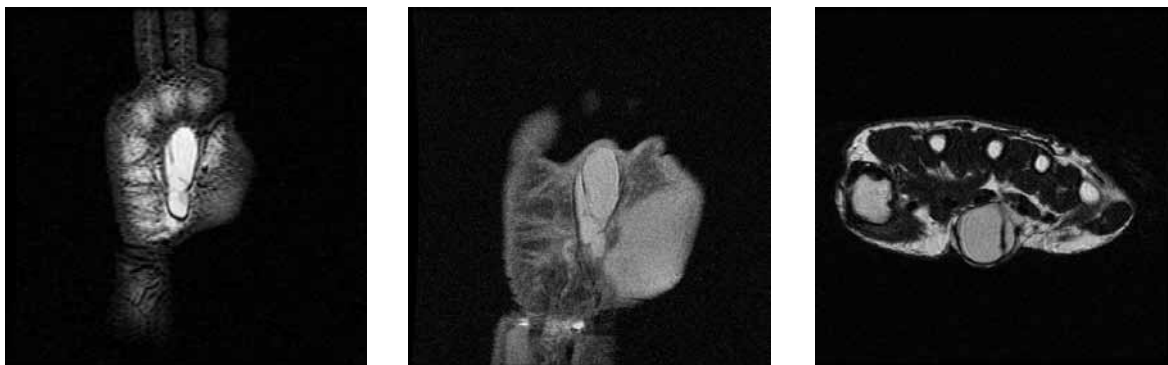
MRI scan of the cystic tumor
